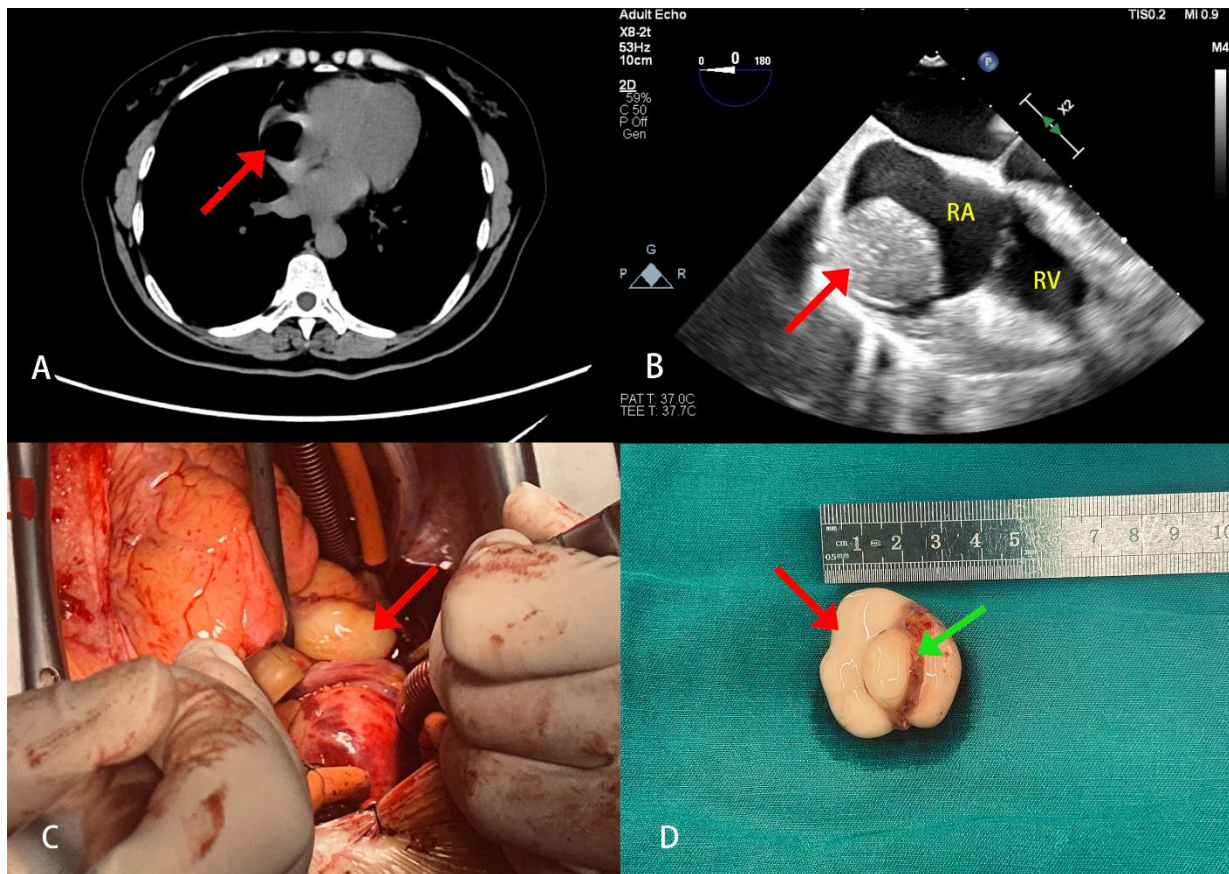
A: Chest CT indicates a fat-density nodule within the right atrium, measuring approximately 3.0 cm x 2.5 cm in size (red arrow); B: TEE reveals a mass in the right atrium with a broad base, closely connected to the right atrial wall, without signs of tricuspid valve obstruction (red arrow); C: Intraoperative exploration identified a yellow, smooth-surfaced mass approximately 3.0 cm x 3.0 cm in size, penetrating the right atrial wall and protruding into the right atrium (red arrow); D: The completely excised right atrial mass (red arrow) and a portion of the right atrial wall (green arrow). RA, right atrium; RV, right ventricle.
